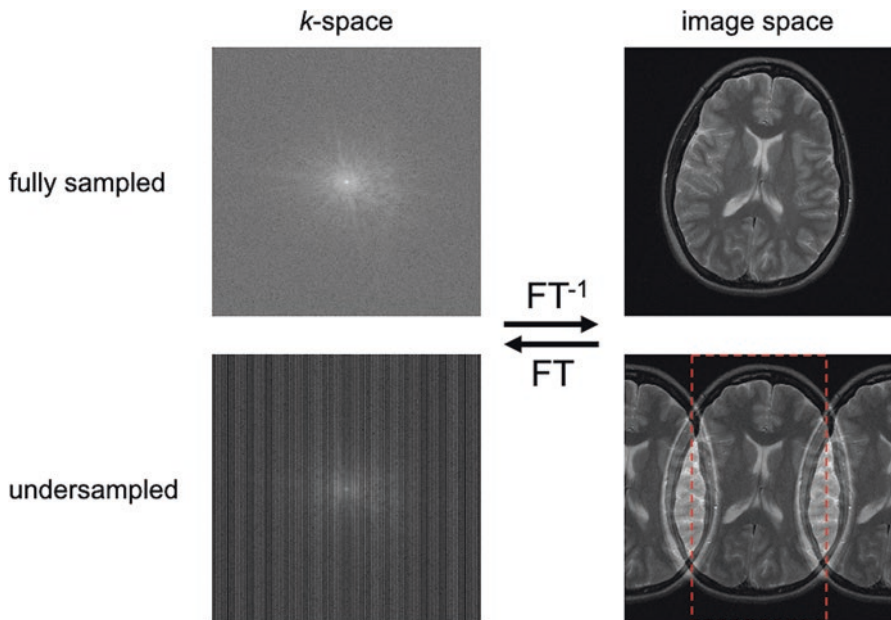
Fourier relationship between k -space and image space in MRI. Utilizing linear field gradients, MRI data are acquired in the space of spatial frequencies, that is, k -space, that is related to the image space through Fourier transform. The extent of the object in image space determines how finely the data need to be sampled in k -space. For the case of equidistant sampling the image FOV is inversely proportional to the k -space sampling interval. If every other line in k -space is omitted the FOV in the corresponding dimension is cut in half (indicated by the dashed red lines). Signal from outside the reduced FOV will then “wrap around” and appear in the wrong location (“aliasing”)
